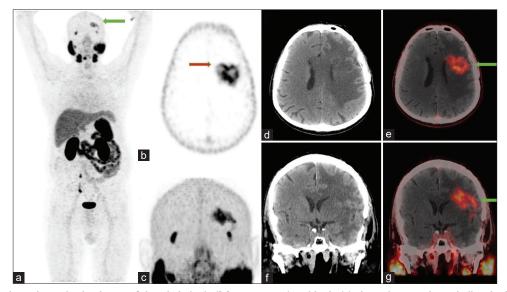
Maximum intensity projection image of the whole body ([a] green arrow) and brain (c) shows increased metabolism in the left frontal lobe. Positron emission tomography (PET) images [b – orange arrow] show hypermetabolism in the left frontal region. Computed tomography (CT) and <sup>68</sup>Ga PSMA 11 PET/ CT scan ([d and e], axial CT and fused PET/CT; [f and g – green arrow], coronal CT and fused PET/CT) shows intense tracer uptake along the periphery of an irregular hypodense lesion in the left frontal lobe
